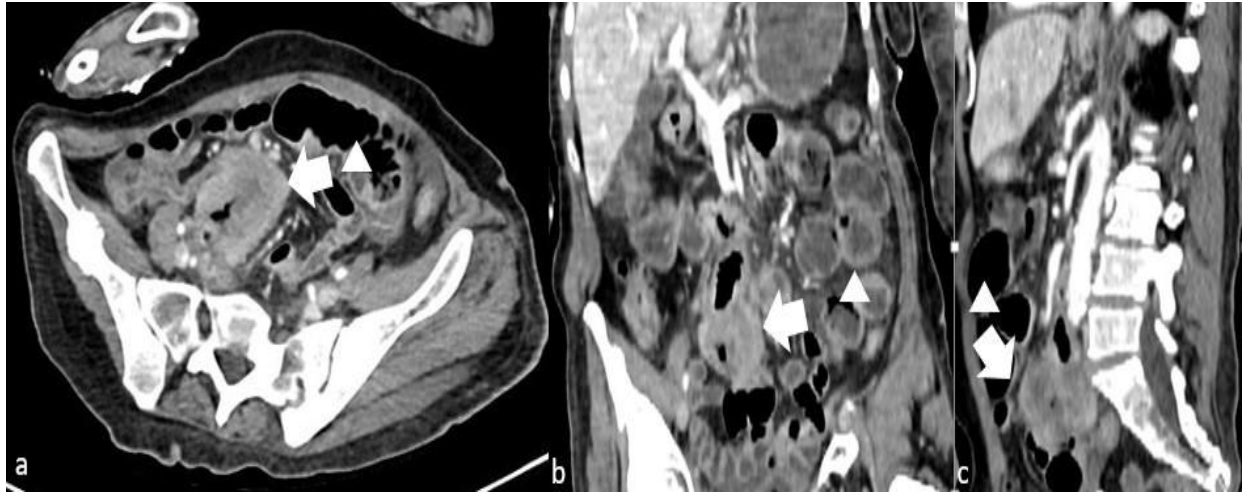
Axial (a), coronal (b), and sagittal (c) contrast-enhanced CT images obtained during the portal venous phase with soft-tissue windowing demonstrate a necrotic mass measuring 6×4.6 cm in the distal ileal segment (white arrows). The regions marked by triangles in panels a, b, and c indicate dilatation of proximal small-bowel loops and air–fluid levels secondary to obstruction caused by the mass.
